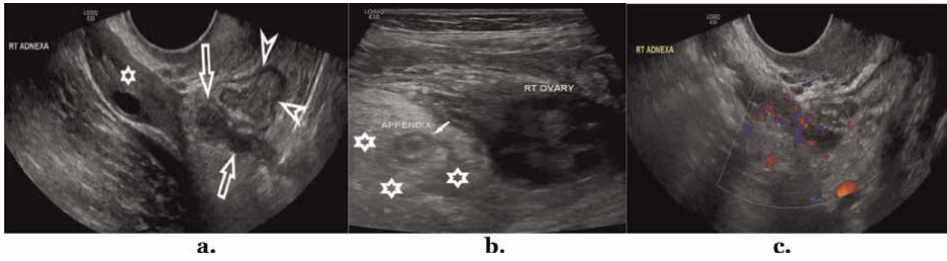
Pelvic appendicitis. A: A transvaginal sonogram of the right hemipelvis showing the right ovary (star), an inflamed appendix (arrows), and a slightly thick-walled adjacent bowel loop (arrow heads) secondary to the inflamed appendix. b: A transabdominal sonogram of the right hemipelvis obtained using a 9 MHz linear transducer with the appendix (arrow) and some echogenic periappendiceal mesenteric oedema (stars), and the normal right ovary medial to it. c: Shows hypervascularity on colour Doppler of the inflamed appendix of the same patient in a.
